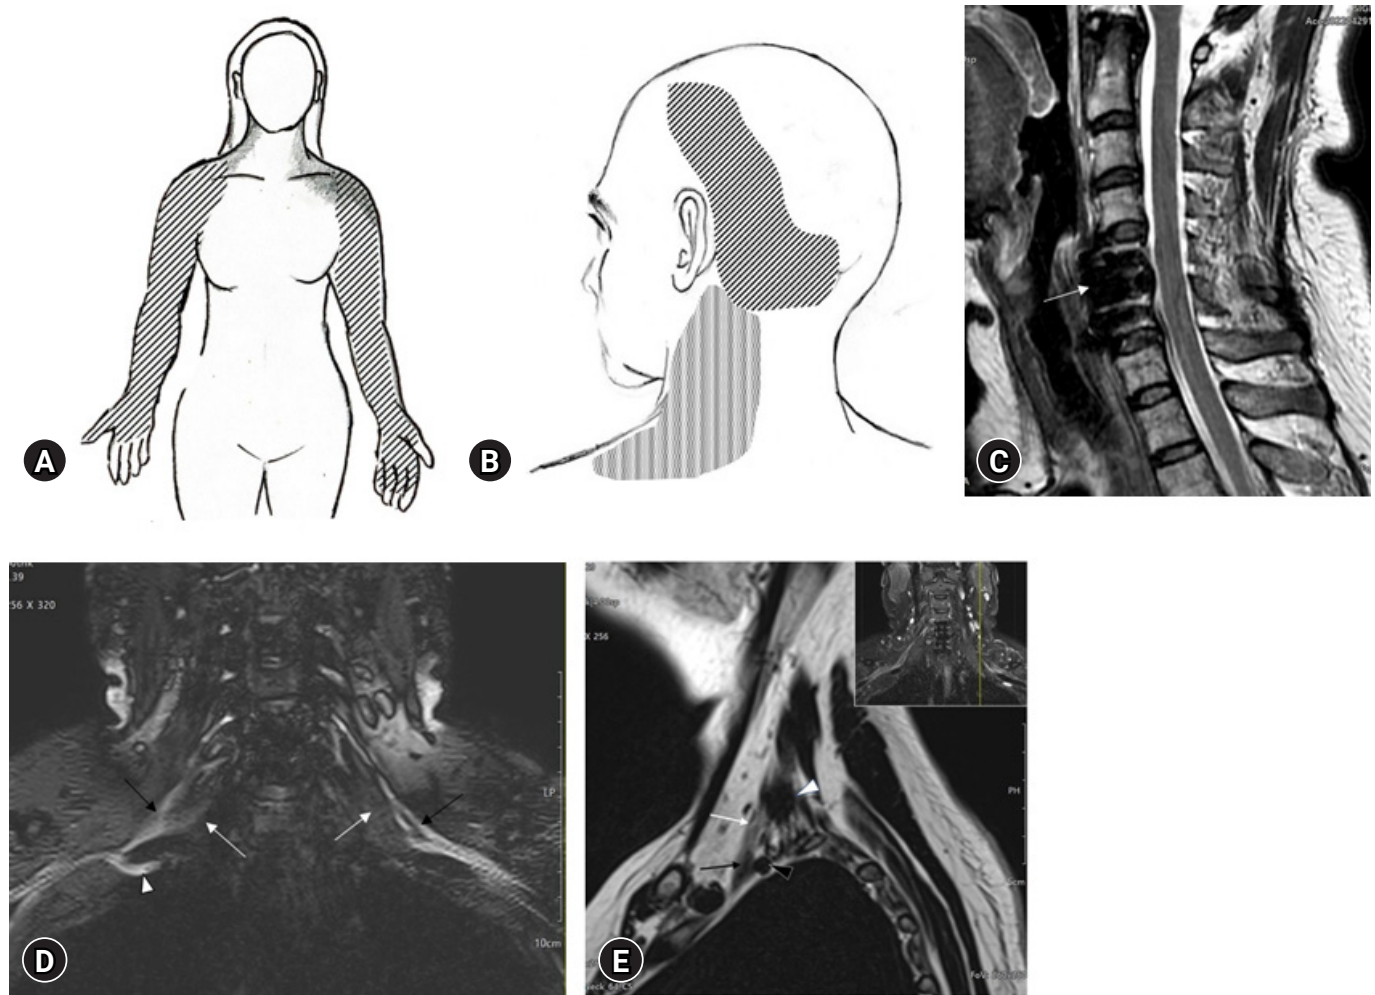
Distribution of bilateral arm pain and radiologic findings. (A) Distribution of pain and paresthesia (hatched area) in the bilateral arms and hands. The gray area indicates the distribution of the aching pain associated with arm paresthesia. (B) Distribution of aching and tightening pain in the left occipital area. It radiated to the temporoparietal vertex and posterolateral neck. (C) Sagittal T2-weighted magnetic resonance imaging of the cervical spine showing no abnormality, except for prior C5/6 anterior cervical discectomy fusion (arrow). (D) A coronal T2-weighted, enhanced, short tau inversion recovery image of the brachial plexus showing suspected hypertrophy of the anterior scalene muscle (white arrows) and interdigitation of the contour of the brachial plexus (black arrows). Deviation in the course of the lower trunk of the right brachial plexus (white arrow) was noted. (E) A sagittal T2-weighted image of the left brachial plexus shows the left brachial plexus (white arrow) leaving the interscalene triangle between the anterior (black arrow) and middle (white arrowhead) scalene muscles. The back arrowhead indicates the subclavian artery.
